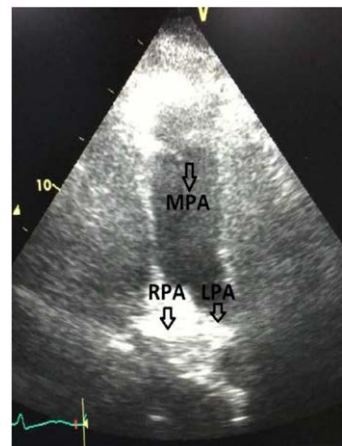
Parasternal short axes view showed a dilated main pulmonary artery, with thrombus occluding the ostium of right and left pulmonary arteries.
